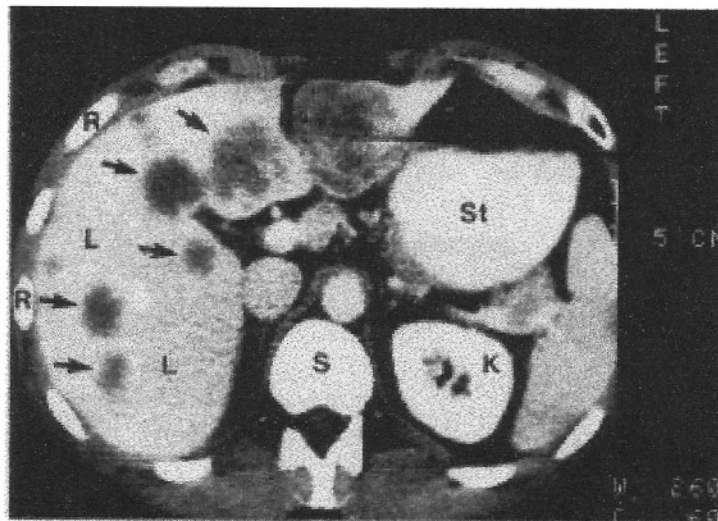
CT scan showing a tomographic slice through the lower abdomen.
